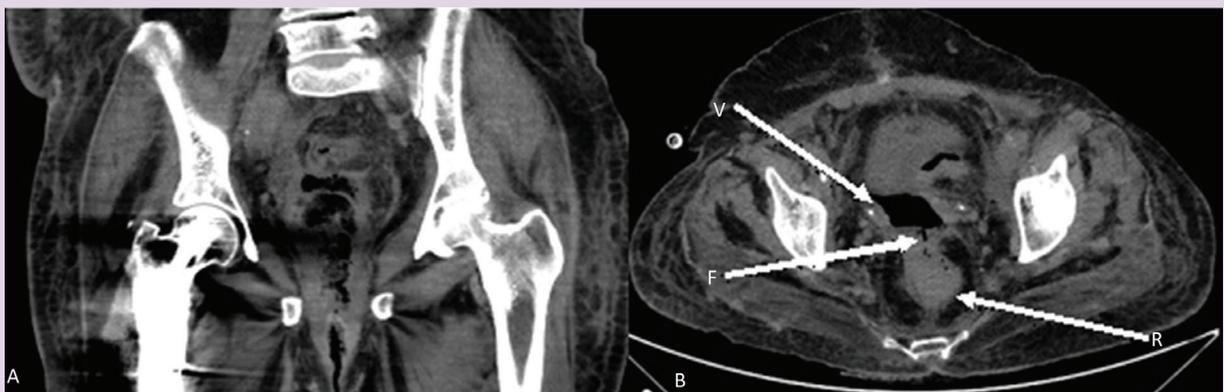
Computed tomography [Coronal (A) and axial (B) planes] revealed rectovaginal fistula tract and peri vaginal air densities.
